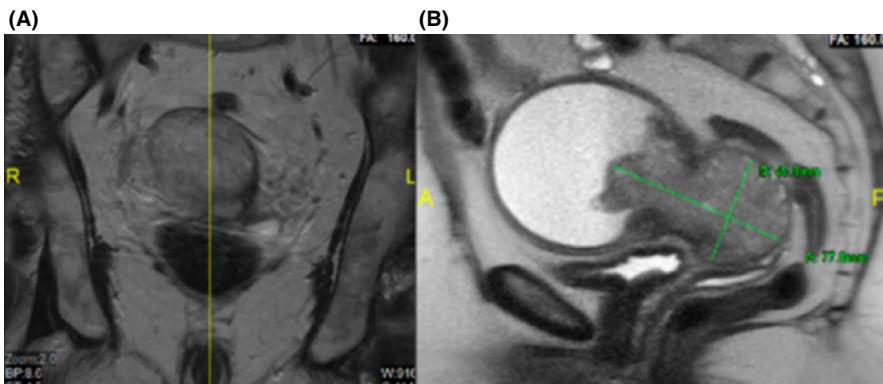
A, B, CT pelvis with contrast showing heterogeneously enhancing, lobulated mass measuring 4.6 cm AP \times 6.0 cm transverse \times 7.8 cm cranio-caudally, expanding the endometrial cavity up to 6.7 cm
